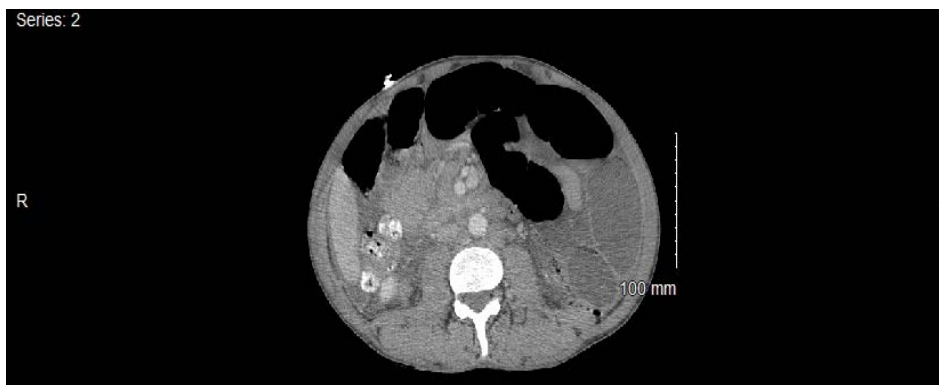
Abdominal CT scan revealed dilated small bowel consistent with small bowel obstruction.
